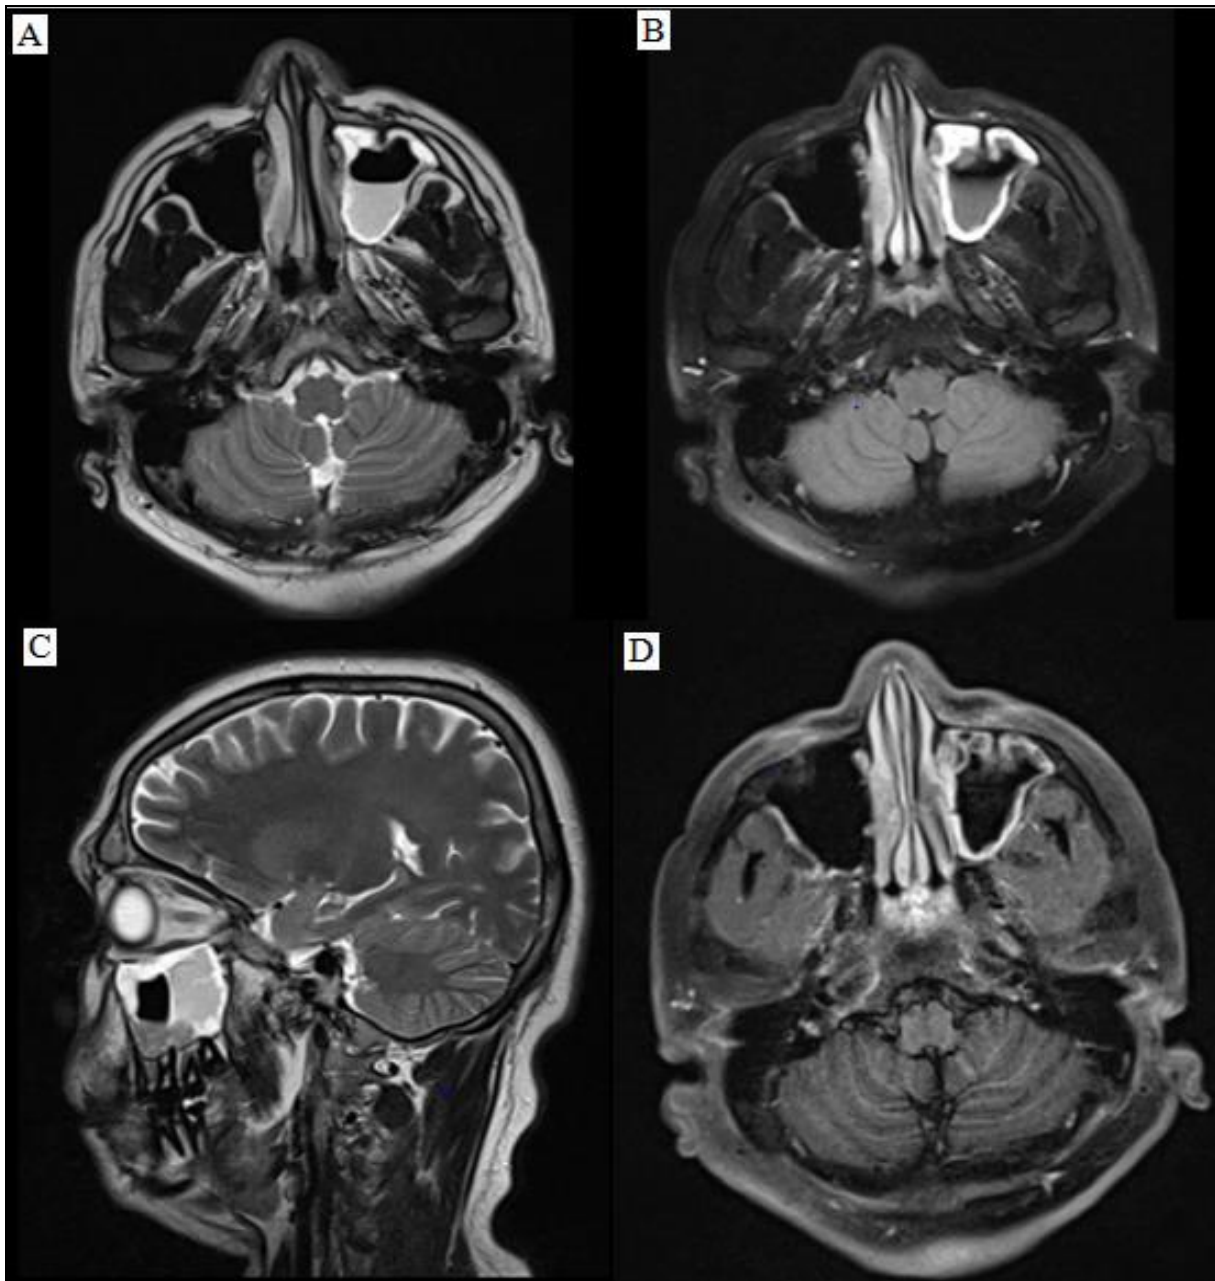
A 29 years old male patient presented with fever, right sided nasal obstruction (A&B) T2WI and STIR images shows heterogeneously isointense soft tissue lesion demonstrating in the right ethmoid sinus and sphenoid sinus with mucosal thickening with expansion of right posterior ethmoid sinus which bulges into the medial wall of right orbit without obvious intraorbital extension. (C&E) Axial and coronal T1 post contrast images shows minimal enhancement of the lesion. (E) HRCT thorax shows multiple areas of ground glass opacities with superimposed interlobular septal thickening predominantly involving lower lung fields bilaterally with multiple thin walled cavitary lesions.
